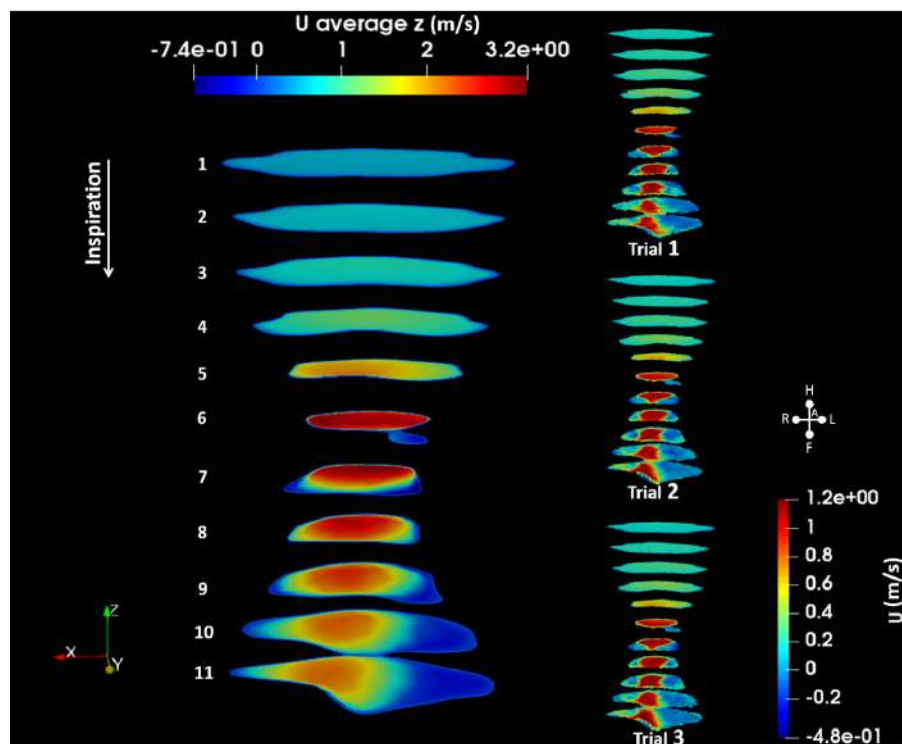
Velocity distribution in all chosen slices of the pharynx model during inspiration in CFD and 2D PC-MRI trials.
